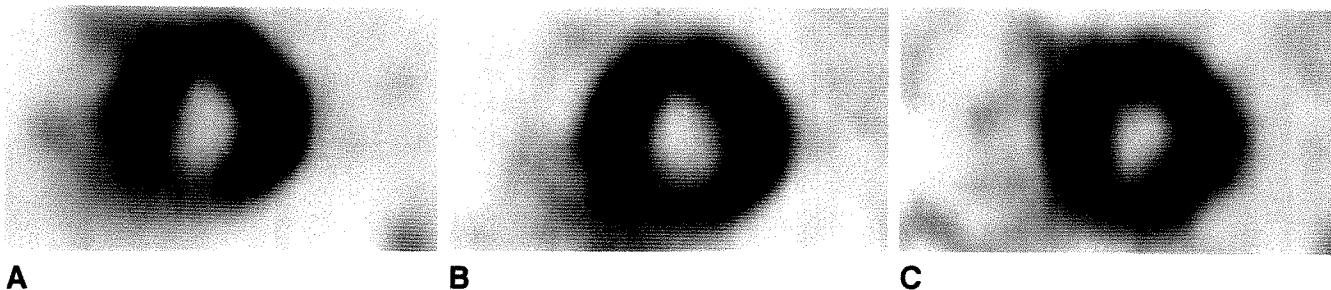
A–C, Exercise stress single-photon emission CT ²⁰¹Tl study shows short-axis slice imaged immediately after stress (A) and at 4 (B) and 24 (C) hr. Anterior and inferior walls have progressive redistribution over time. These changes are consistent with severe ischemia and markedly delayed redistribution of ²⁰¹Tl activity.
